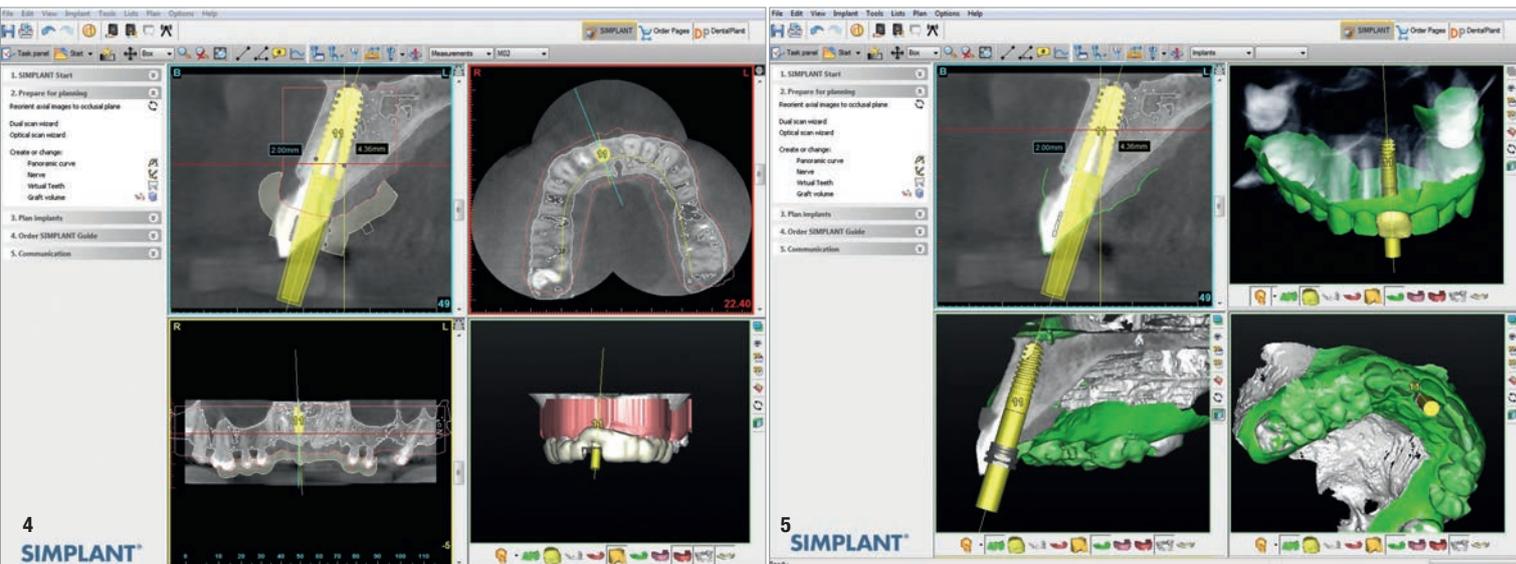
Designing the guide in the Simplant software based on the planned implant position. Fig. 5: Overlaying the CBCT and CEREC intra-oral scans, as well as the planned implant position, in the Simplant software.
